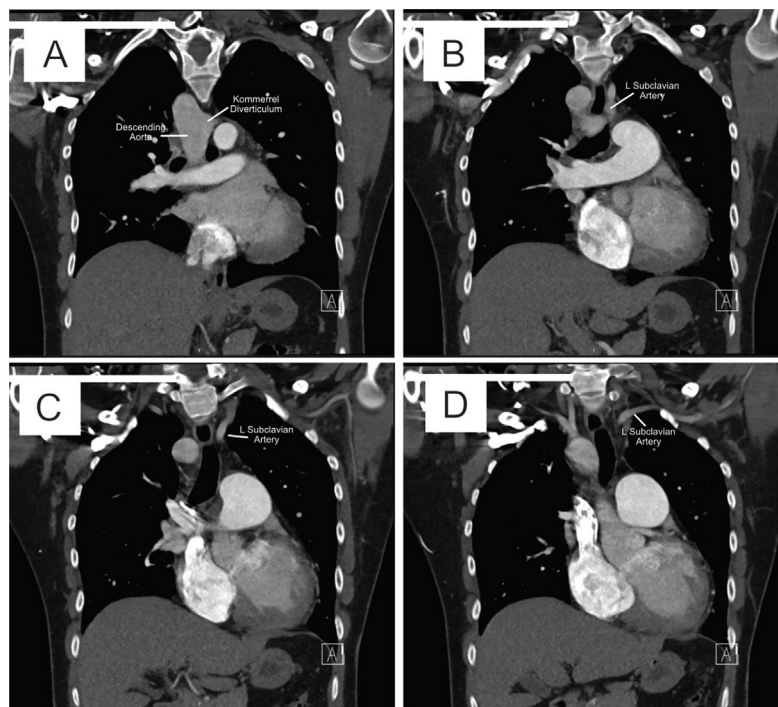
Coronal slices of CT pulmonary angiography, outlining the Kommerell diverticulum and aberrant course of the left subclavian artery. Slices are displayed from posterior (A) to anterior (D). Note the left subclavian takes a retro-tracheal course, as seen in (B/C).
